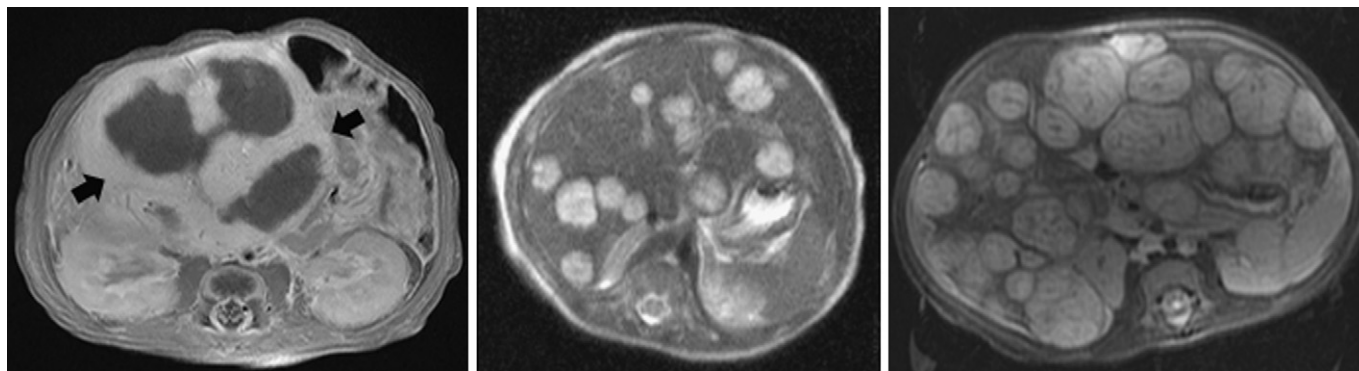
Axial magnetic resonance images of hepatic hemangioma. T1 postcontrast appearance of a focal hepatic hemangioma (*left*), which demonstrates peripheral enhancement (*arrows*) with sparing centrally due to thrombosis or scar. T2 images of multifocal hepatic hemangioma (*middle*). Lesions are hyperintense relative to liver. T2 sequences of diffuse hepatic hemangioma show near-total hepatic parenchymal replacement (*right*).
